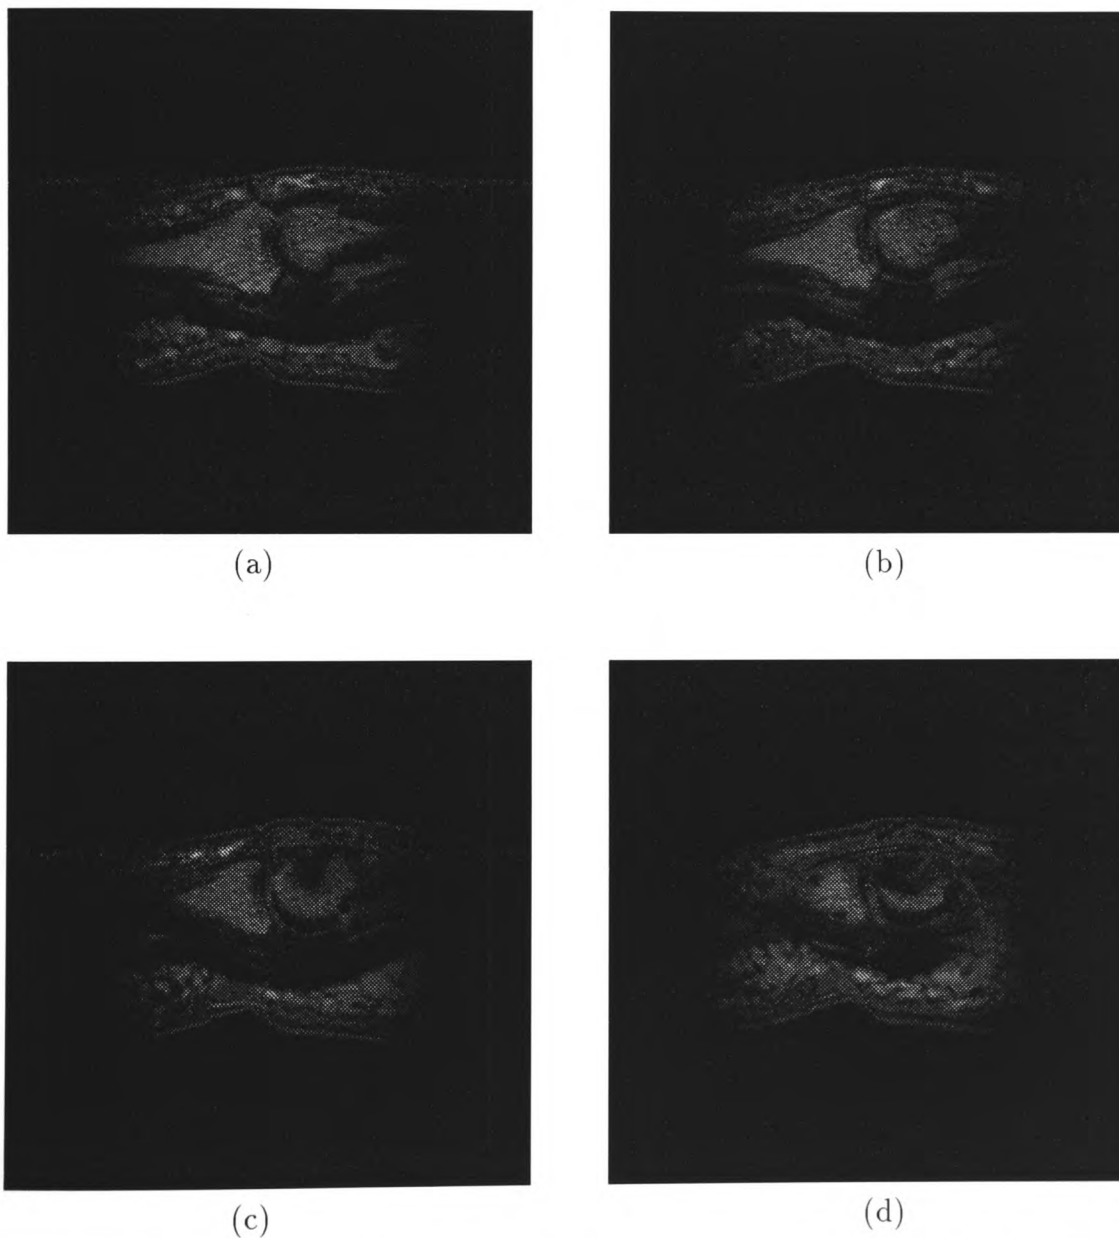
(a) to (d) Subject 1 standardised second occasion T2-weighted image slices 1 to 4 respectively.
